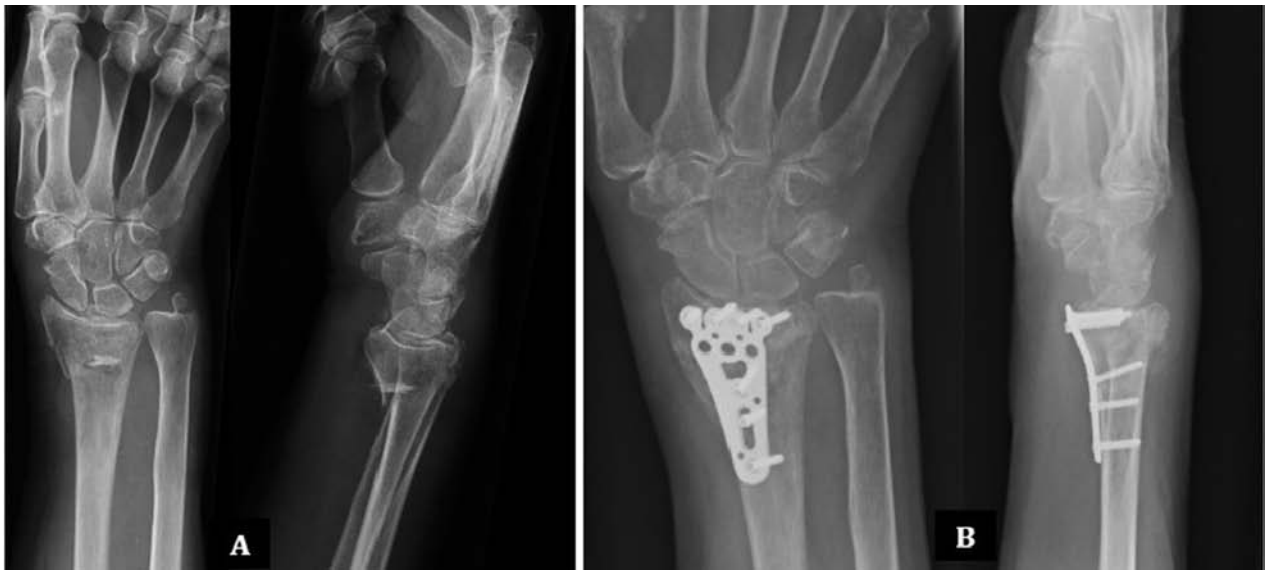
A: 65 years old woman with many fragments fracture of the distal radio. B: radiographic check 3 months after surgery: synthesis with angular stability plate Aptus Radius
